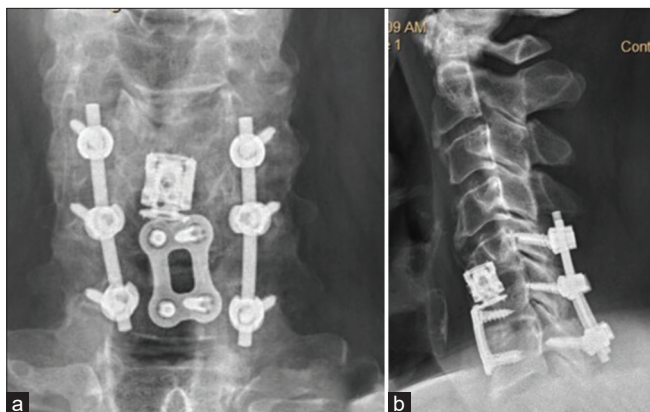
No Change in the (a) Anteroposterior (AP) and (b) Lateral Cervical X-rays Obtained 2 Months and 2 Years Following the C56 Anterior Cervical Discectomy and Fusion (ACDF) and Posterior C5-C7 Instrumented Fusion. The AP (a) and Lateral (b) Cervical X-rays obtained 2 months and 2 years following the C56 ACDF and C5-C7 posterior instrumented fusion showed no changes in the location of the anterior (C56 ACDF) or posterior (C5-C7 fusion) instrumentation.
